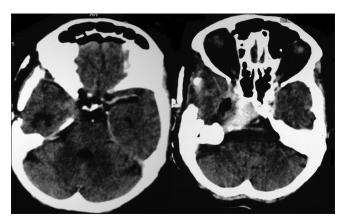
Postoperative computed tomography scan (axial images) with contrast: Adequate decompression of middle cranial fossa portion with residual tumor in cavernous sinus and petrous apex
